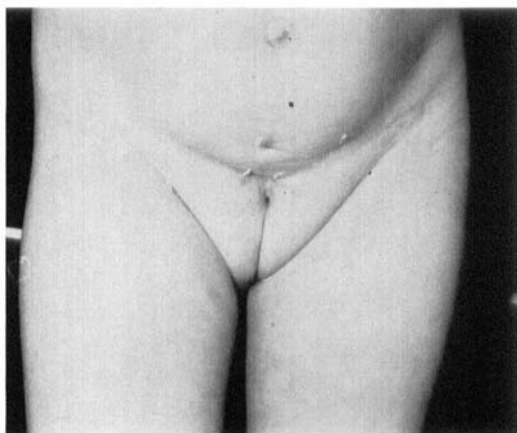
Case No. 1. 3. The initial X-ray of the pelvis develops a 4.2 cm diastasis between the osseous parts of the pubic bones. 4. Slight decrease of the diastasis immediately after bilateral iliac osteotomy. 5. After reconstruction of the symphysis and fixation of the pubic bones with a wire loop the diastasis decreased to 1.4 cm. The transplanted bone is not visible at the X-ray.
